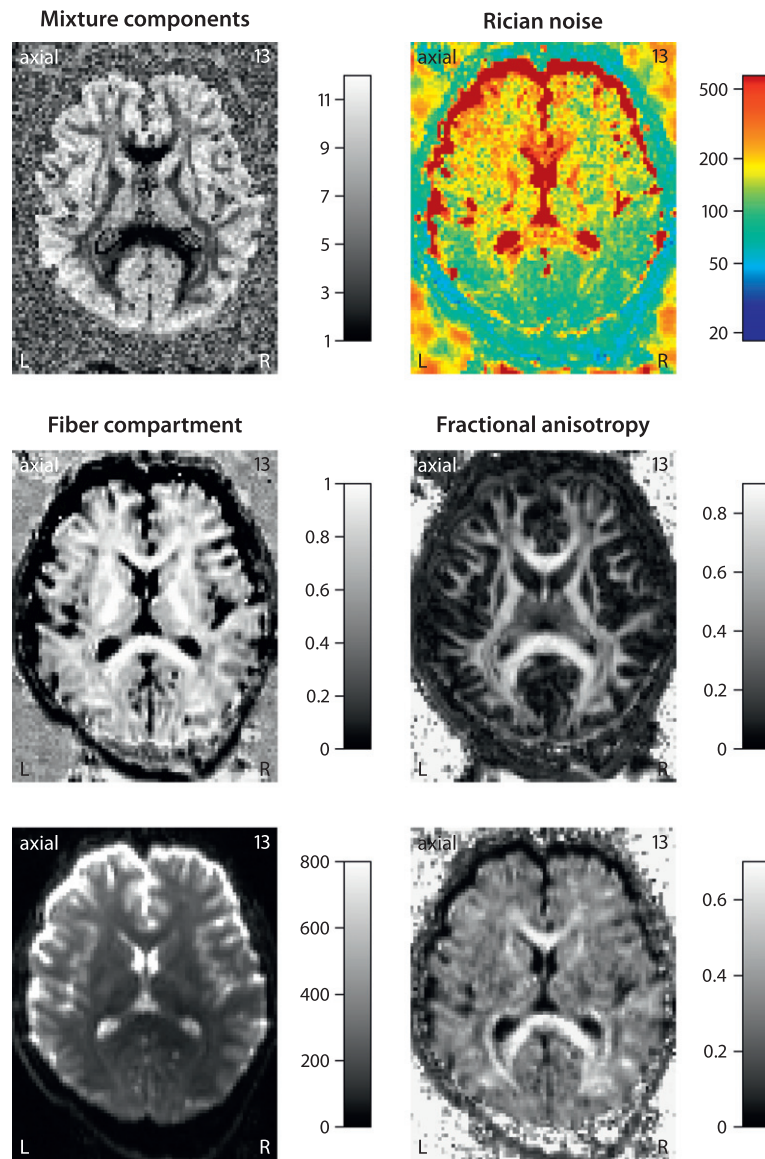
The upper two rows show the estimation of the number of mixture components k , the Rician noise level ζ^2 , the volume fraction of the fiber compartment $1 - P_{iso}$, and the fractional anisotropy of the diffusion tensor model. The bottom row exemplifies an MR image without diffusion weighting (left) and the diffusion signal for one of the gradient directions with a b -value of 1500 s/mm^2 .
